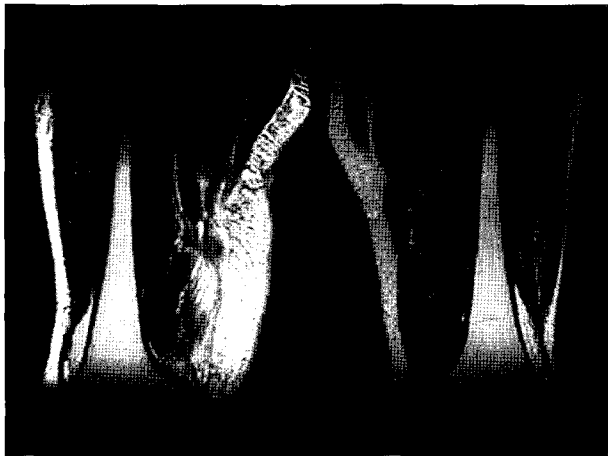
MR image of the right thigh of the patient, showing swelling on fat layer of thigh, but no definitive necrotizing fasciitis.
